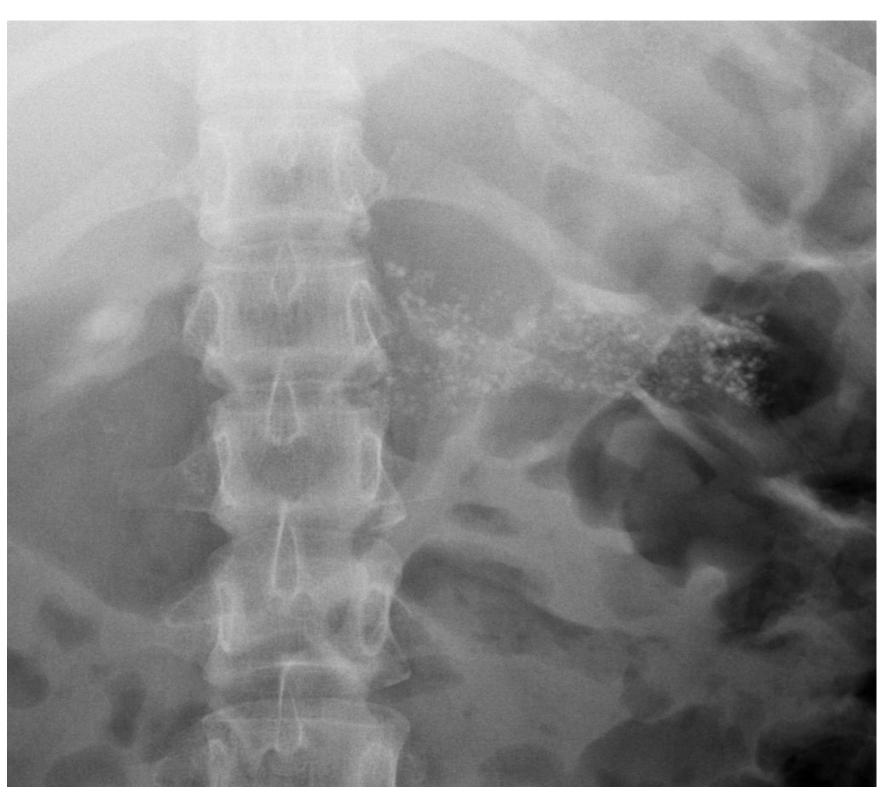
radiography of the stomach and duodenum
